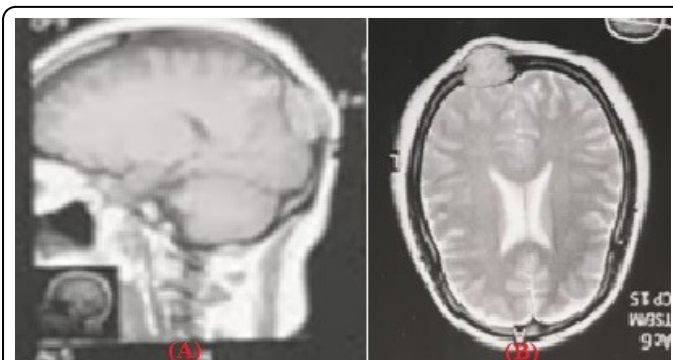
Cerebral MRI showing a lesion of the parieto occipital region in iso-signal T2. a): sagittal section; b): axial section.
